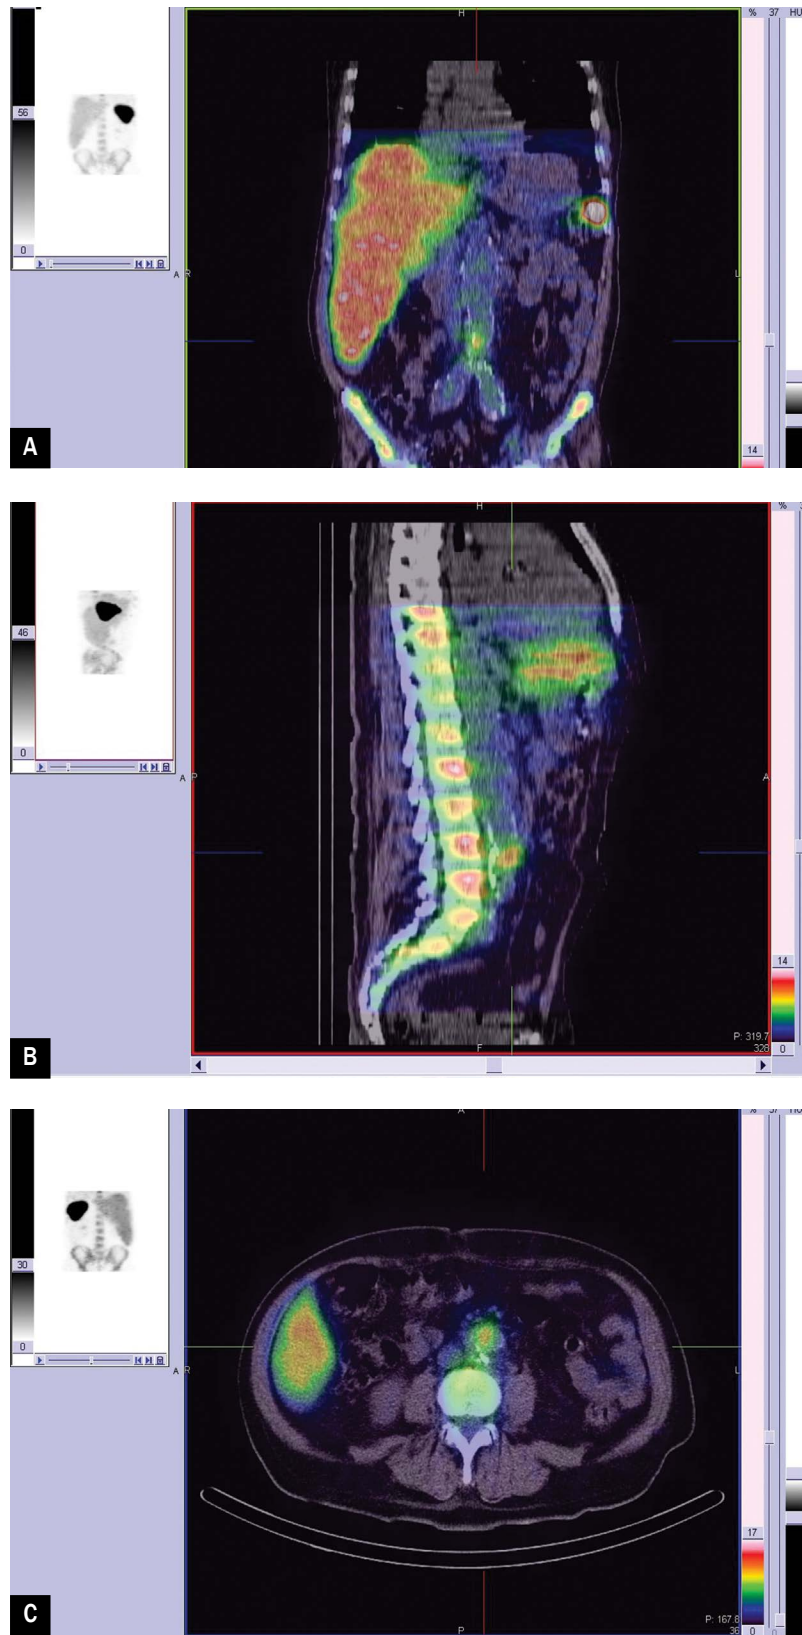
A-C. In SPECT-CT acquisition after 4 h, pathological accumulation of labelled leukocytes localized in the aorta stent-graft confirm infection
